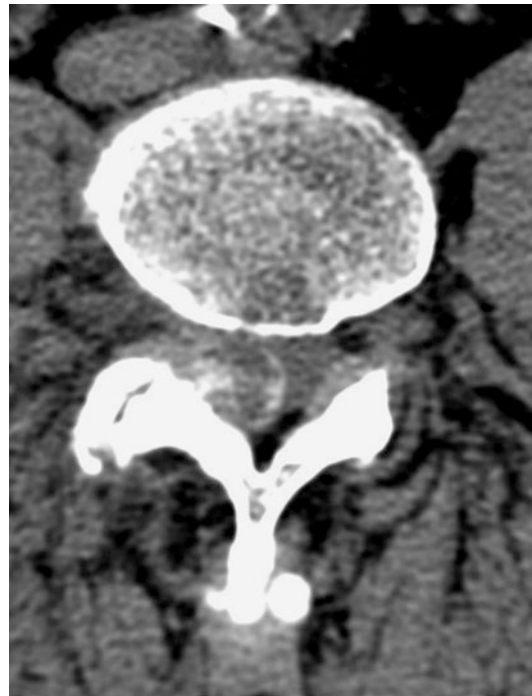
Axial CT image of a large synovial cyst having calcified walls originating from degenerated right facet joint. Marked compression of thecal sac
